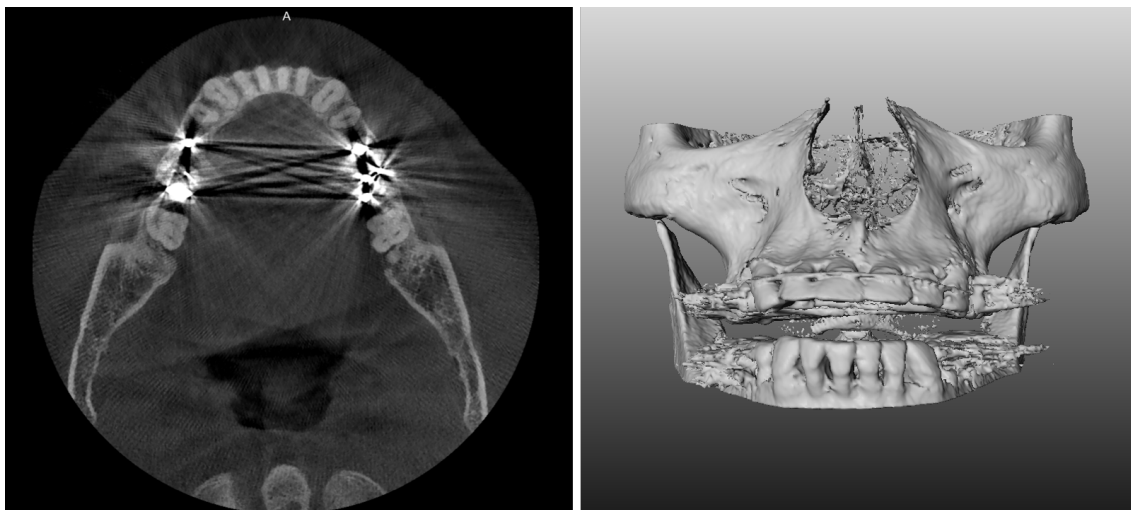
Axial slice of a CBCT image corrupted by metal artifacts (left) and the corresponding three-dimensional rendering of hard tissue structures (right)
